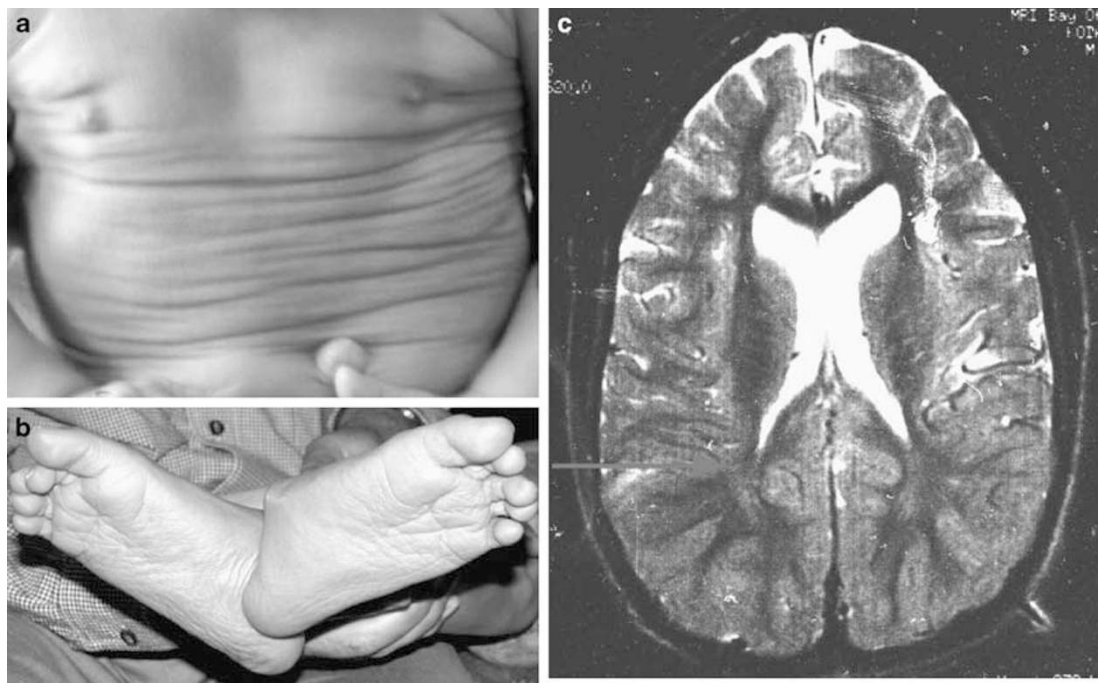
Phenotype features of the new neurocutaneous disorder segregating in a consanguineous family. Lax skin is shown in (a) abdomen of a 6-month-old baby and (b) soles of feet of a 9-year-old child. (c) T₂ axial MRI brain scan of individual IV-4 demonstrating marked underdevelopment of the white matter particularly in the peritrigonal region of the cerebral cortex. Regions of the insular cortex nearly about the margins of the ventricles (red arrow).
